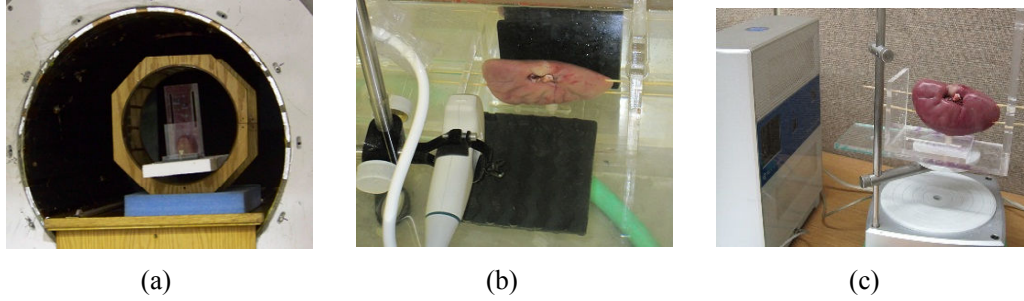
Experiment setup: (a) MRI, (b) ultrasound, (c) optical (laser) scanner
